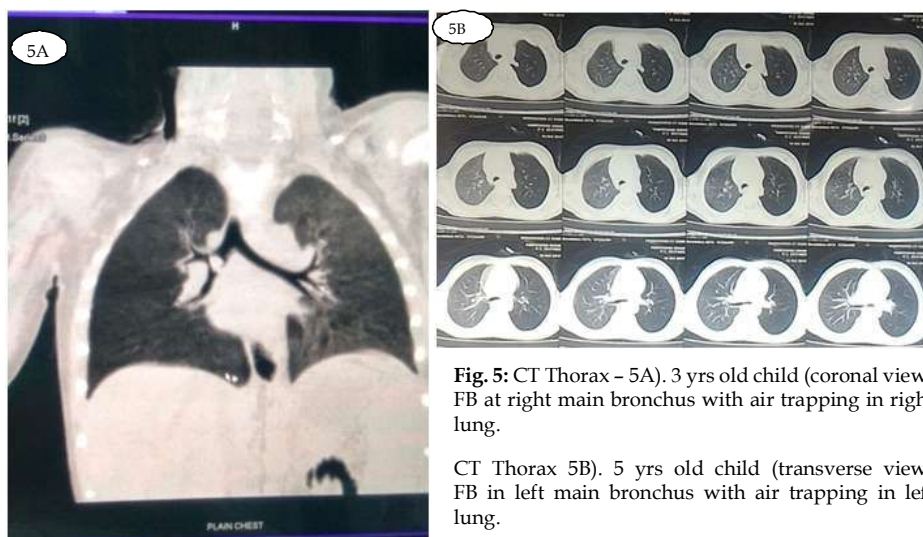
CT Thorax - 5A). 3 yrs old child (coronal view) FB at right main bronchus with air trapping in right lung.
